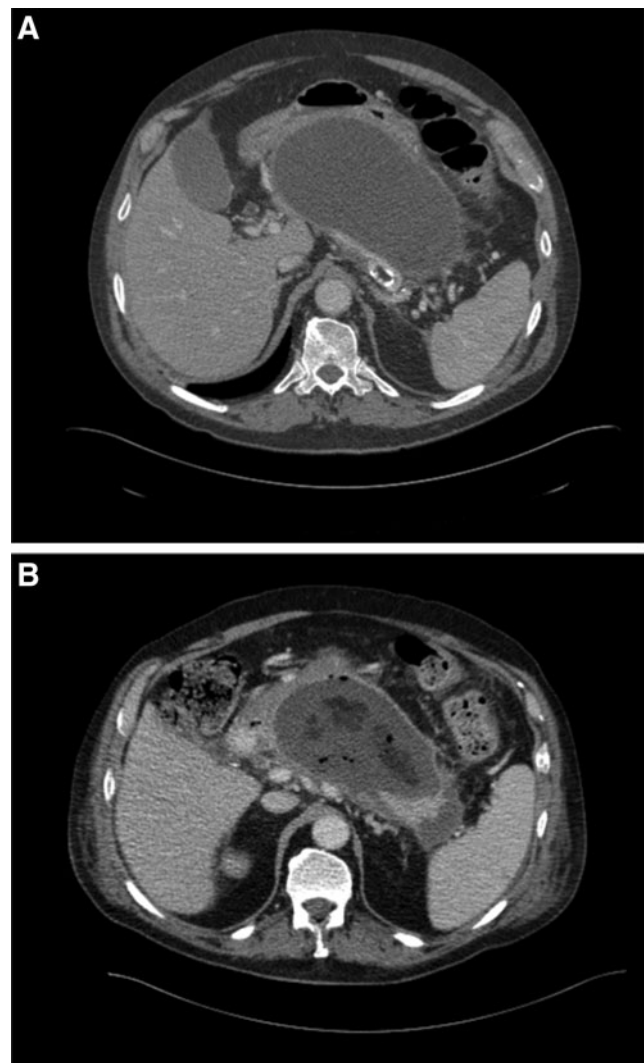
(A) Computed tomography of abdomen on day 50 after presentation showing a large cystic lesion replacing most of the pancreas and measuring approximately 19×10 cm in diameter. (B) Computed tomography of abdomen obtained on day 69 revealing fluid collection with presence of gas bubbles, suggesting infection.
